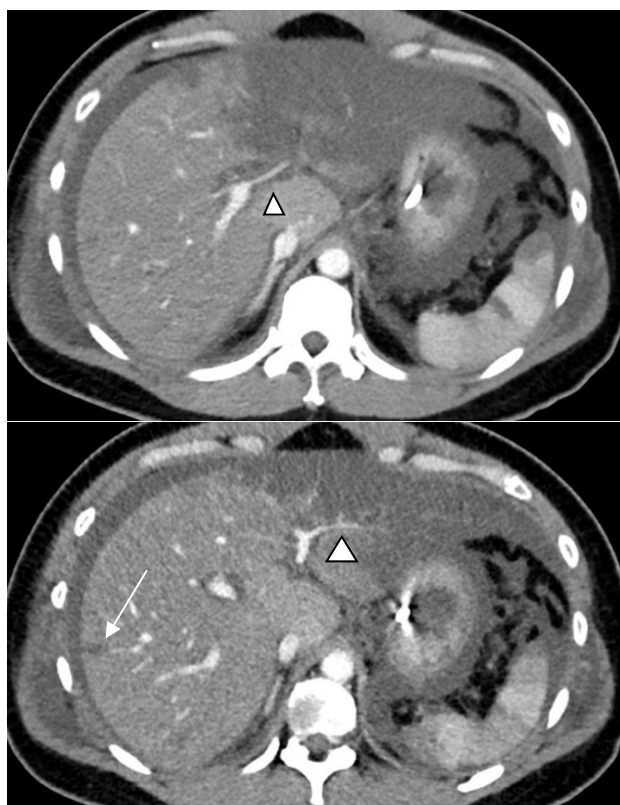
Abdominal contrast-enhanced CT imaging at presentation on selected slices showing narrowing of the left portal vein (arrowhead). Ill-defined areas of hypoenhancement in the left liver lobe and smaller areas in the right liver lobe (arrow) suggest hypoperfusion. Note that there are also wedged-shaped hypoenhancing areas in the spleen, also suggesting hypoperfusion.
